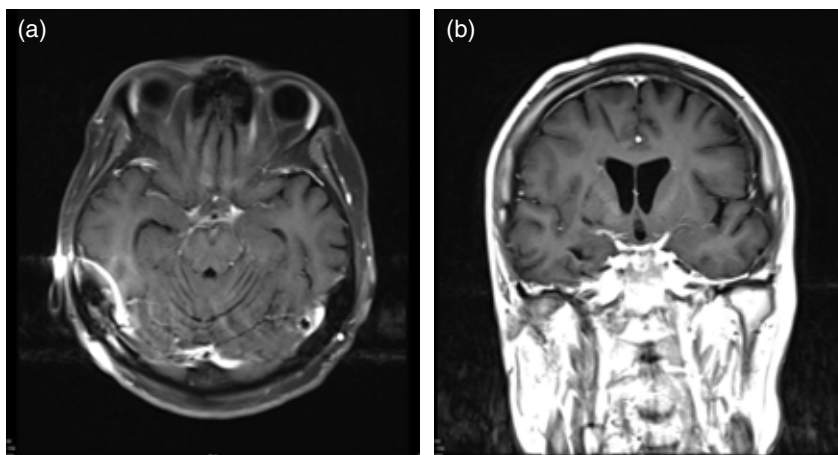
Seven-month follow-up gadolinium-enhanced T1 axial image (a) and coronal MRI scan (b) show significant shrinkage of the basilar meningitis, but hydrocephalus persisted.
